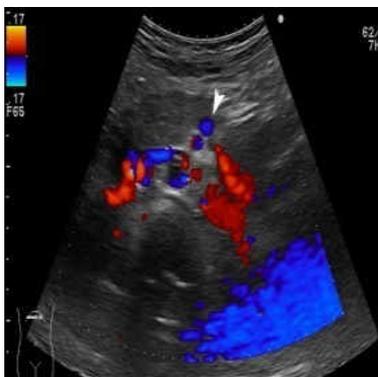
Transverse ultrasound image on admission showing the dislocation of the mesenteric vein (arrow) to the left of the artery.
